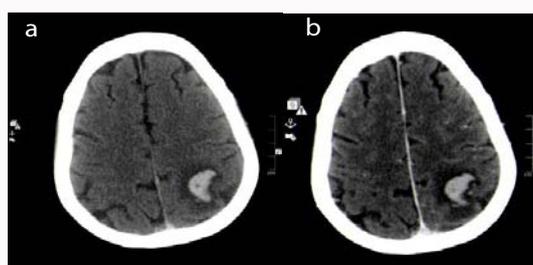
(a) Non-enhanced CT head demonstrates a left parietal lobe hemorrhage and hyperdense Superior Sagittal Sinus (SSS). (b) On the post-contrast CT head, empty sella sign is difficult to appreciate as the clot in the SSS is hyperdense.
